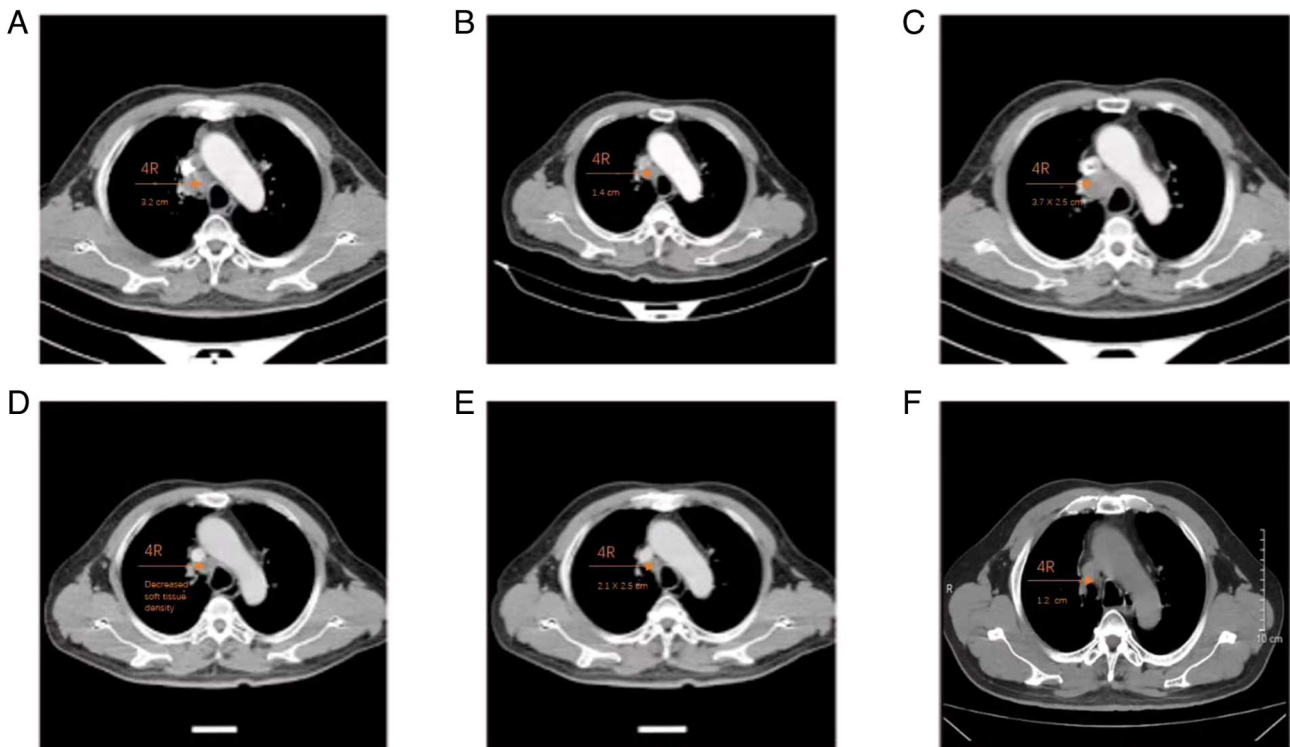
Axial CT images at representative treatment stages in a patient with pulmonary carcinoid. (A) Initial diagnosis (April 2023): Contrast-enhanced chest CT showing a left upper lobe endobronchial lesion (not visible at this level) and an enlarged mediastinal lymph node at station 4R (not annotated), with a maximum diameter of ~3.2 cm. (B) Post-radiotherapy (November 2023): Significant reduction in size of the 4R lymph node, with the maximum diameter decreasing to 1.4 cm. (C) Before systemic therapy (August 2024): Re-enlargement of the 4R lymph node to 3.7x2.5 cm, indicating disease progression. (D) After one cycle of systemic therapy (September 2024): Decreased soft tissue density in the 4R lymph node region. (E) After two cycles of therapy: Continued regression of the lesion, meeting the criteria for stable disease. (F) Surveillance (November, 2025): No newly emerging lesions and further lesion size shrinkage, indicating partial response. CT, computed tomography.
